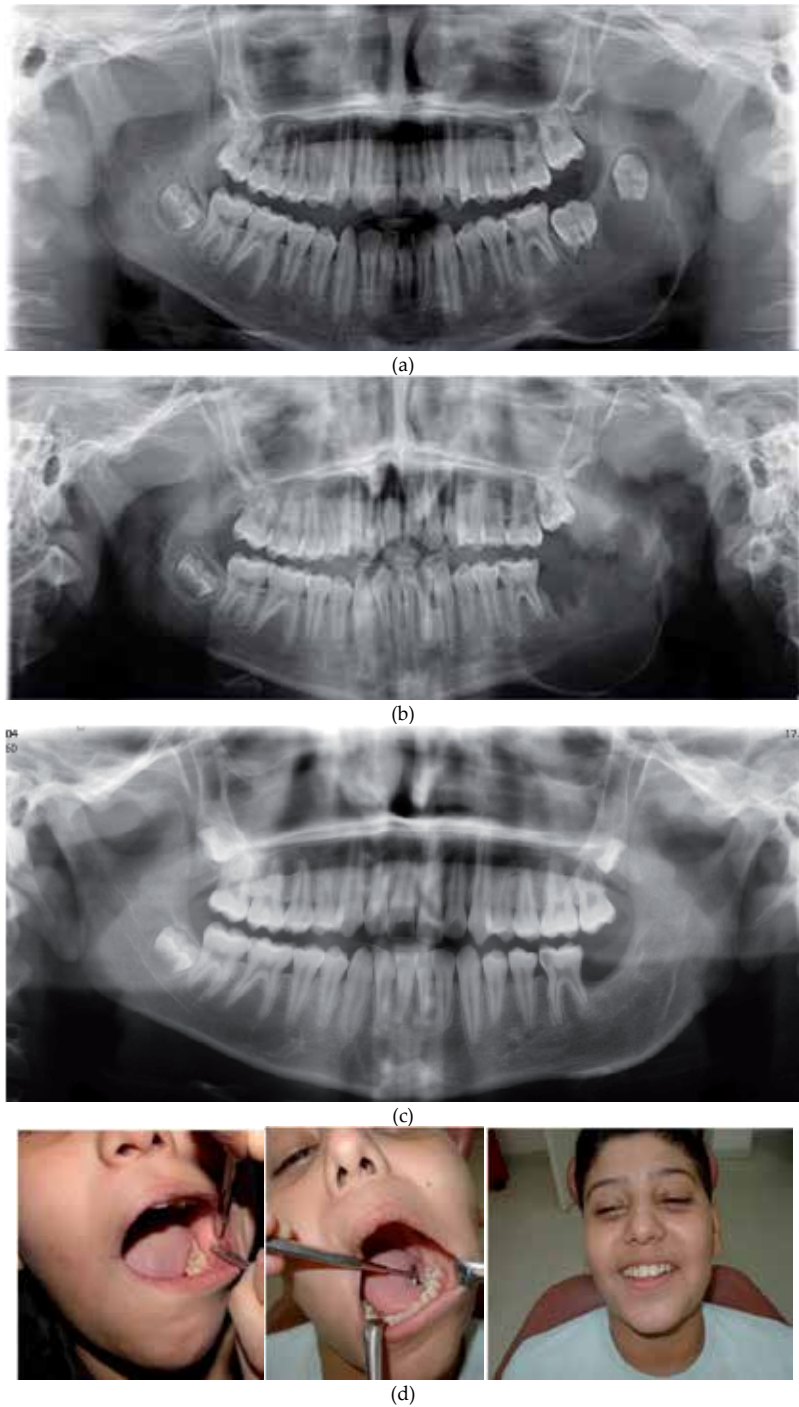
(a): Ameloblastoma: Orthopantomograph of a 12-year-old boy who had a painless bony- hard swelling of the left mandible associated with cortical expansion. (b): Radiological appearance after surgical treatment. (c): Radiological appearance taken 24 months post-operatively. (d): Presurgery photographs showing the left mandible associated with cortical expansion and postoperative clinical control at 12 and 24 months
